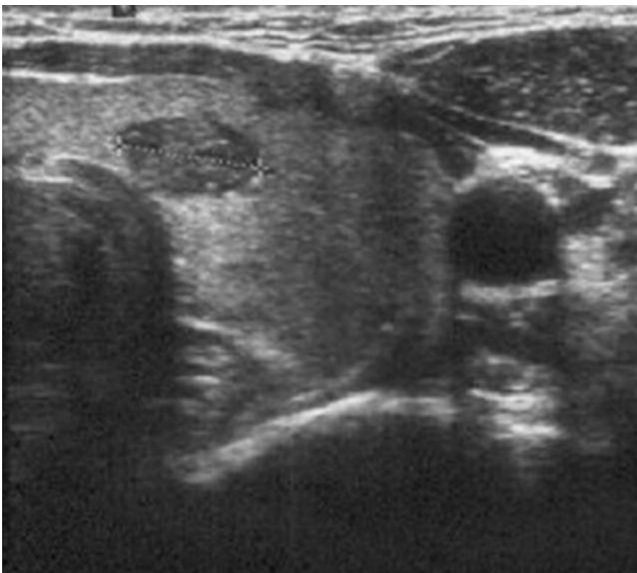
41-year-old woman with papillary carcinoma. Sonogram of left lobe of the thyroid gland shows 0.9 cm, oval, well-defined smooth, hypoechoic nodule with peripheral hypoechoic rim.
